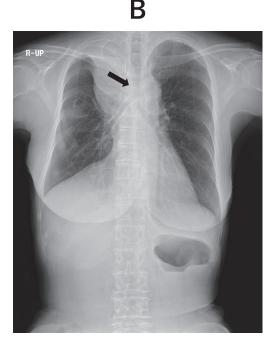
Bronchoscopy and chest X-ray film in case 2A: Tracheal lumen prior to stent placement: The trachea is compressed in the dorsal direction.B: Chest X-ray film after stent placement: Stent expansion is good and the airway lumen is maintained.
